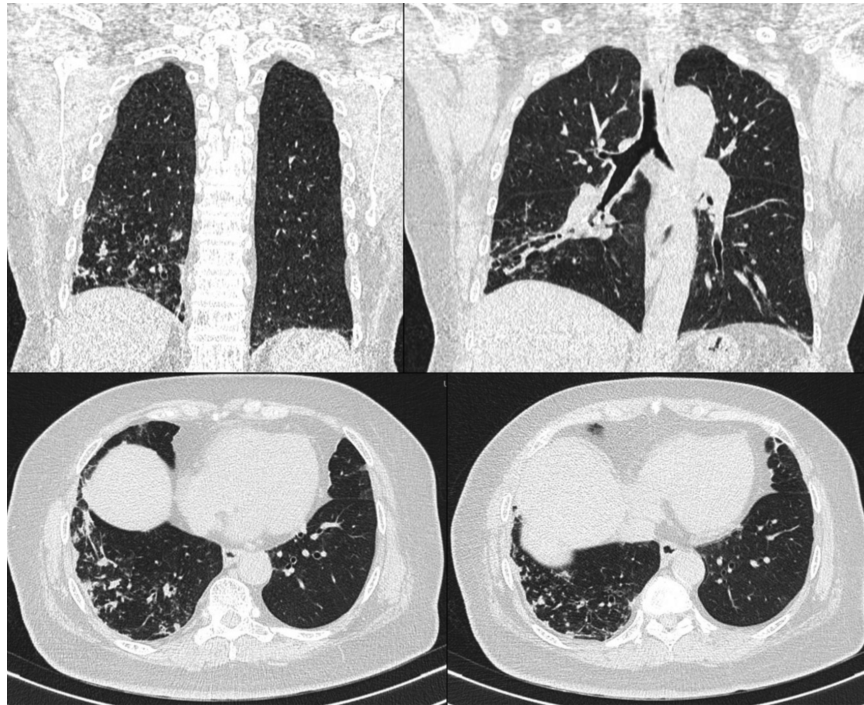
Chest Computed Tomography (CT) shows bibasilar tubular bronchiectasis, bibasilar fibrous lesions diffuse and at the right lower lobe prominent with bronchial wall thickening, fluid retention in some bronchial branches.
